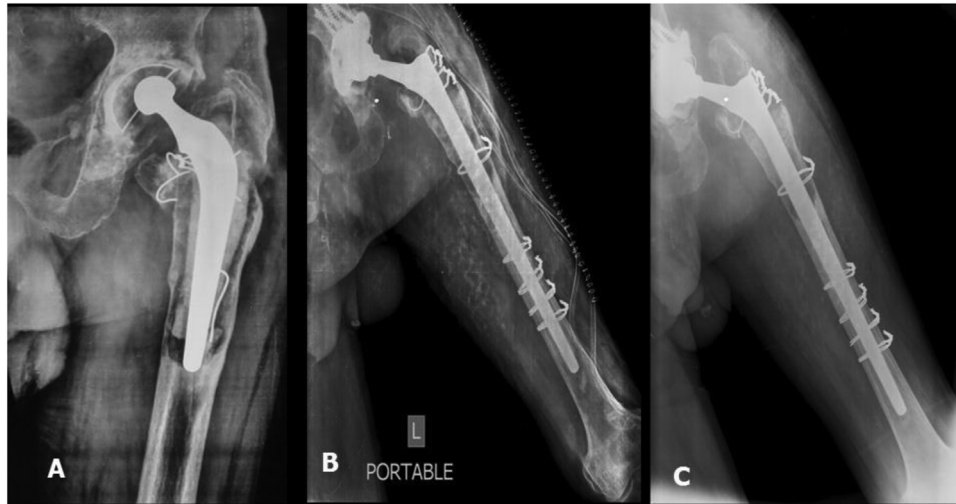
(A) Radiograph of an 81 year old man with severe aseptic loosening of a Charley stem with a Paprosky type IIIA defect (B) Immediate postoperative radiograph (C) Radiograph at 8-year follow-up showing a stable implant and healed osteotomy.
